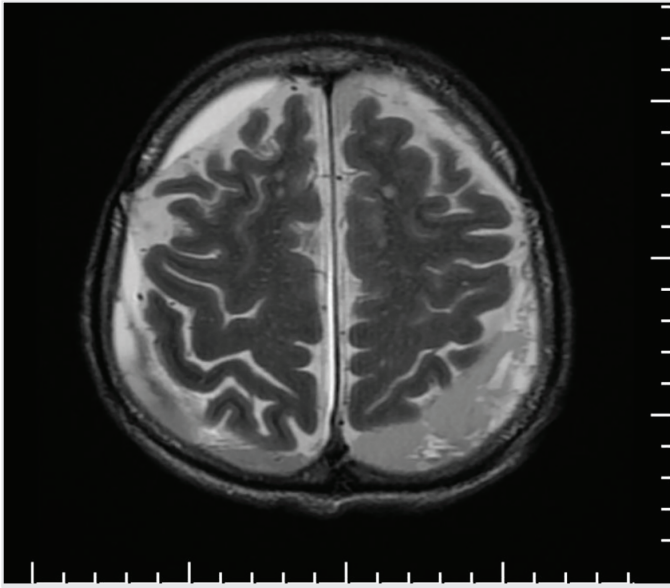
Preoperative axial T2-weighted cranial magnetic resonance imaging reveals chronic hematoma with a thickness of 1.5 cm at its widest point in both subdural spaces
